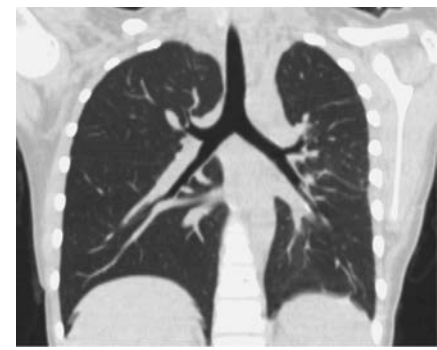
Follow-up computed tomography showed the norm of the left lung on post-operative 12 months.
